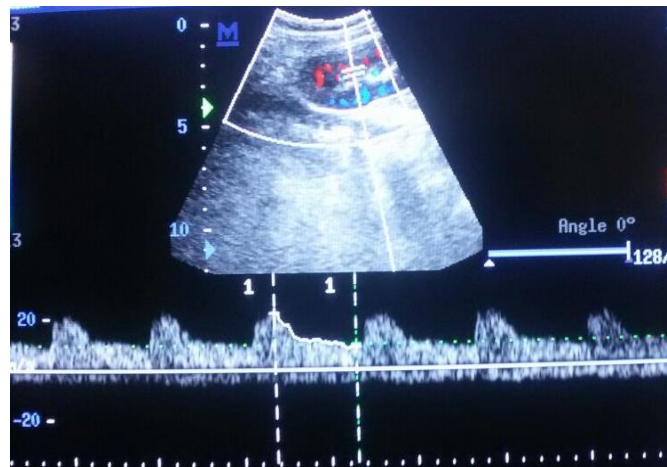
A sonogram of a 17-year-old male shows the normal RI for renal transplant
